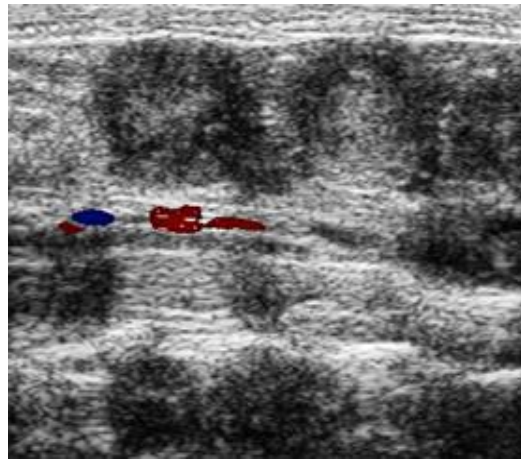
Representative ultrasound image of the uterine artery used for Doppler measurements.
